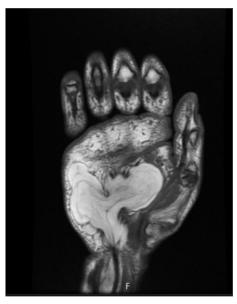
MRI of the hand (T_1)
